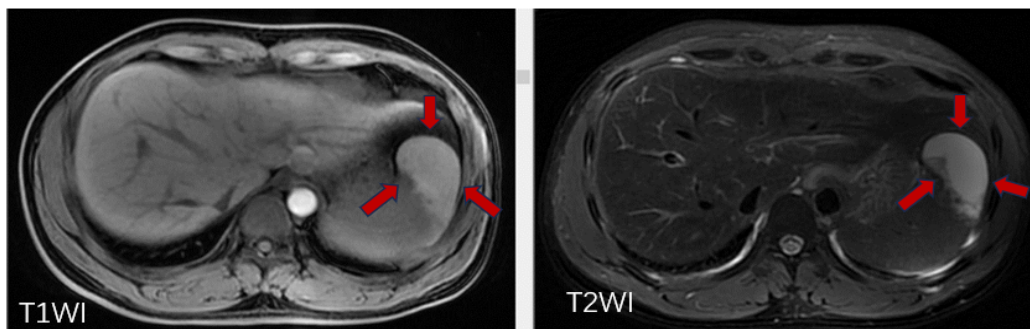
Enhanced MRI: The spleen is slightly enlarged, and cystic abnormal signals are shown in the spleen: hematoma? Subacute stage? (Indicated by the red arrow), both T1WI and T2WI show high signals. A low-signal septal image on T2WI can be seen within the lesion, with the lesion range approximately 6.9 cm × 3.8 cm × 3.2 cm. DWI shows unevenly high signals, and there are a few fluid signal shadows around the spleen.
